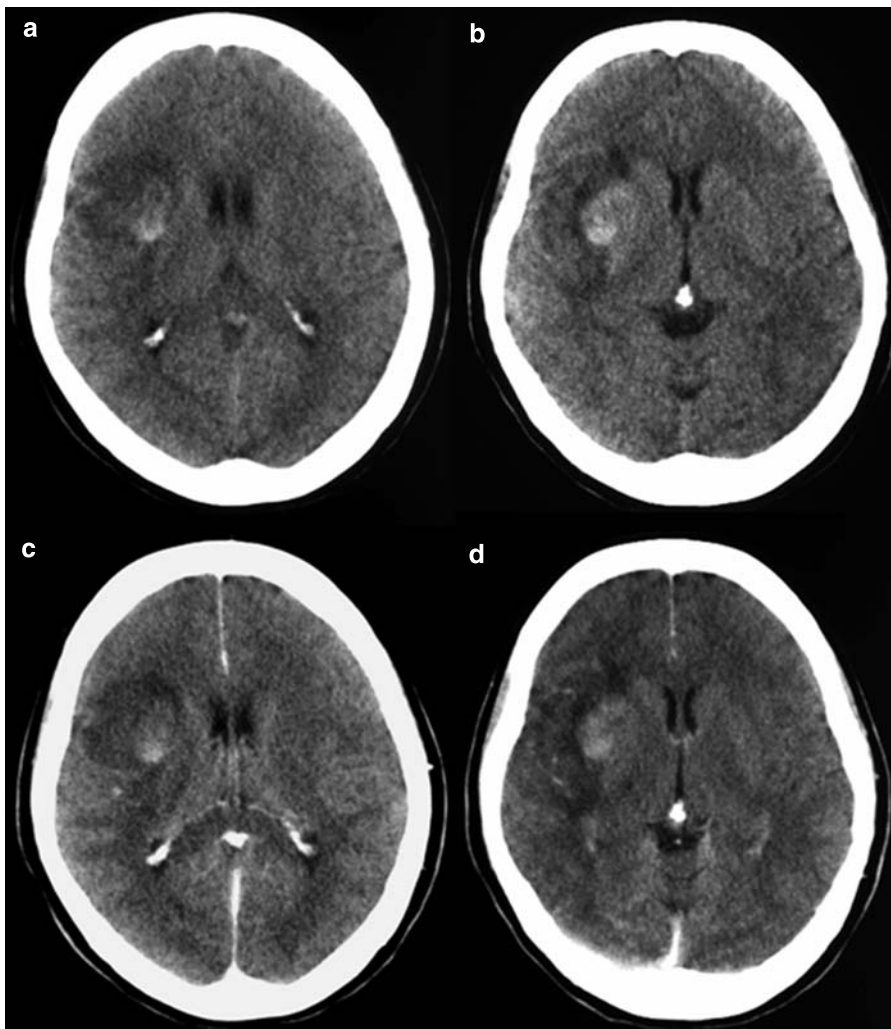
Axial CT before (a and b) and after (c and d) administration of contrast medium: the images show a hyperdense lesion lateral to the right putamen consistent with an intraparenchymal haematoma; there is moderate perilesional edema without contrast enhancement and without significant mass effect
